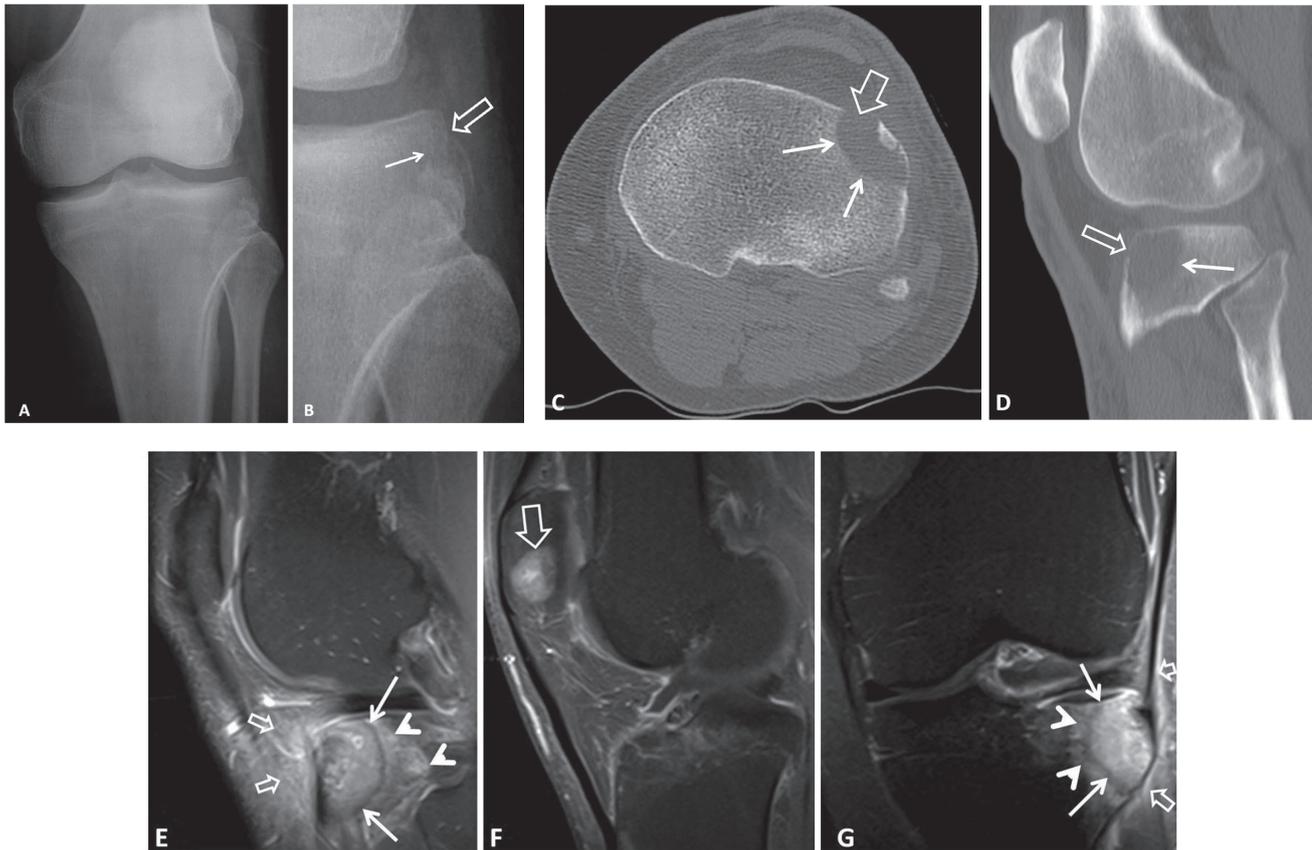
A 44-year-old male patient with primary non-Hodgkin lymphoma of bone. AP radiograph of the knee (A) and magnified view (B). A subtle lucent area on the lateral proximal tibial epiphysis (thin arrow) and cortical disruption (open arrow) are shown. Axial (C) and sagittal reconstruction (D) CT images showing to better advantage the hypodense osteolysis (thin arrows) and the anterior cortical disruption (open arrows). Fat suppressed contrast enhanced T1w MR images in the sagittal (E, F) and coronal (G) planes showing to better advantage the bone marrow involvement in the lateral tibial metaepiphysis (thin arrows), reactive soft tissue changes (short open arrows) and another asymptomatic focus of involvement in the lower pole of the patella (open arrow). Reactive bone marrow oedema surrounds the malignant lesion (arrowheads).
